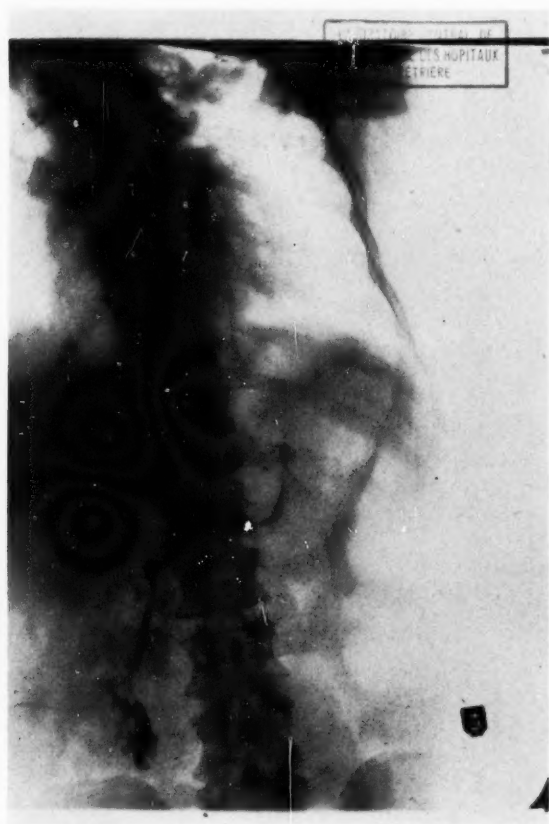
Visualization of Wirsung's duct during an operation for cholelithiasis. Normal roentgen appearance. Note extremely oblique course of Wirsung's duct.
